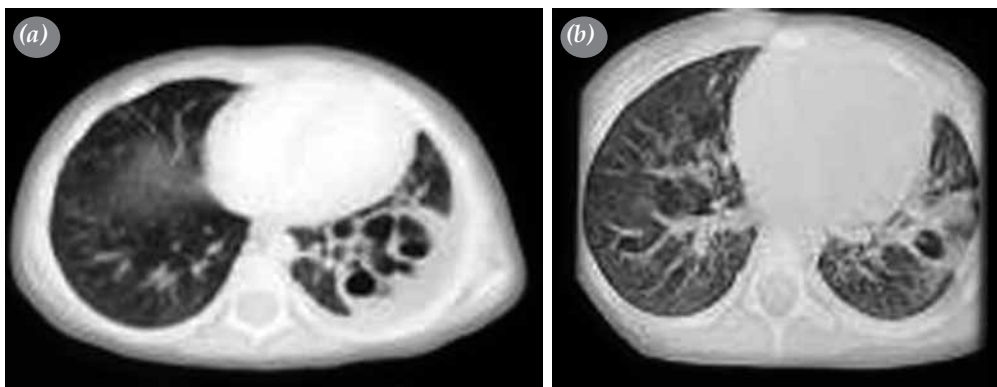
(a) Multiple cavities in the left lung before medical treatment. (b) Thoracic computed tomography image after a month of medical treatment.
